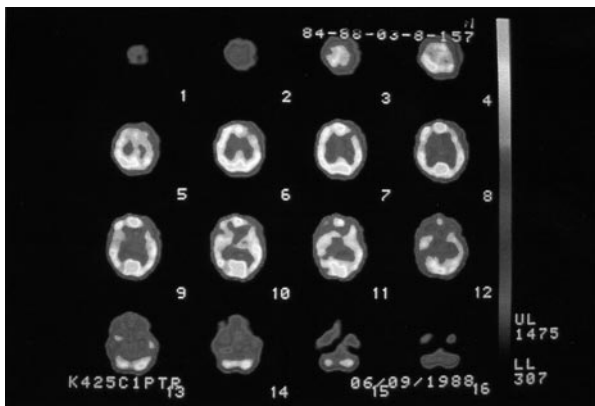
The 1988 Image of the Year, by Devous et al., was obtained with a three-detector SPECT scanner using technetium-99m ECD.
